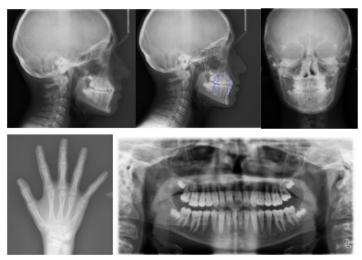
Post treatment Radiographic Figures
